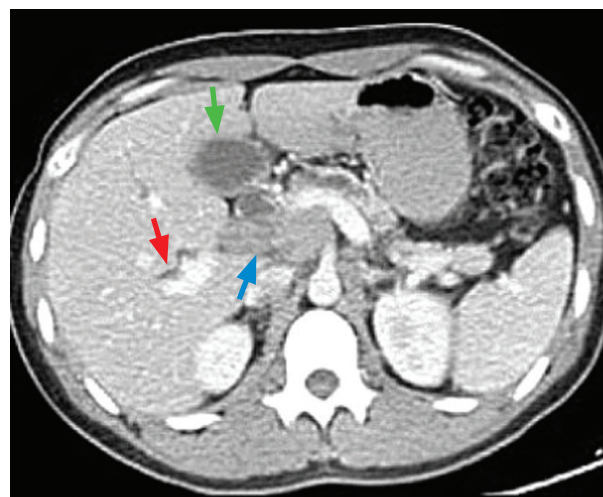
CT abdomen showed an ill-defined hypodense mass at pancreatic head measuring about 3.0 x 3.5 x 4.2 cm (blue arrow) with distended gallbladder (green arrow) and dilated intrahepatic duct (red arrow).
